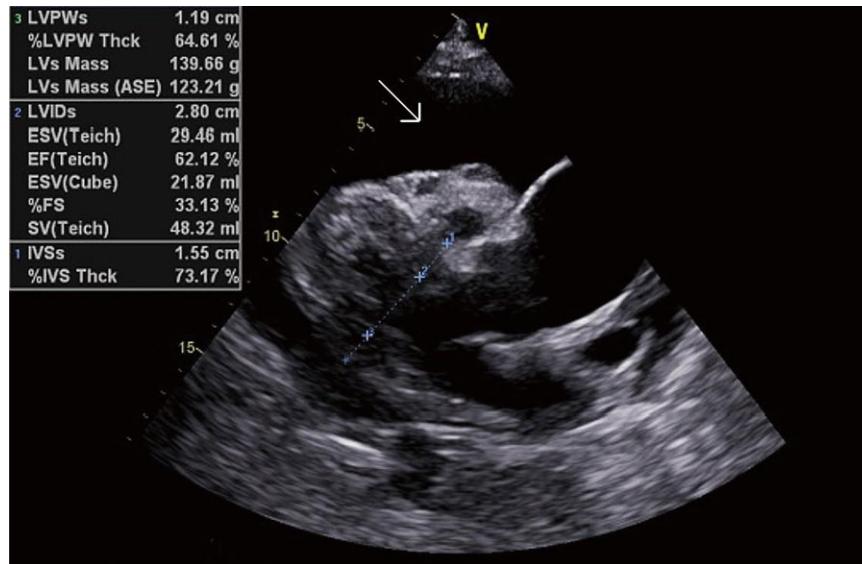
Echocardiography showed massive pericardial effusion.
